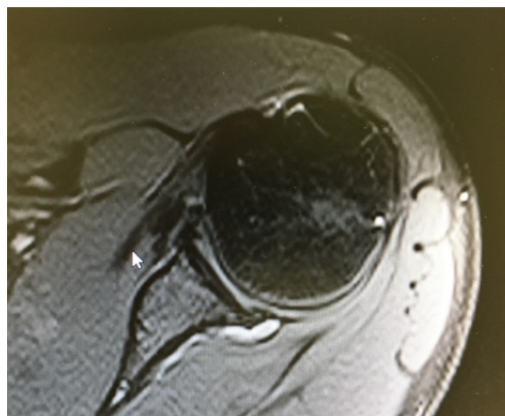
Edema and posterior bone cyst of the humeral head + posterior labral tear with paralabral cyst on shoulder MRI with internal conflict
